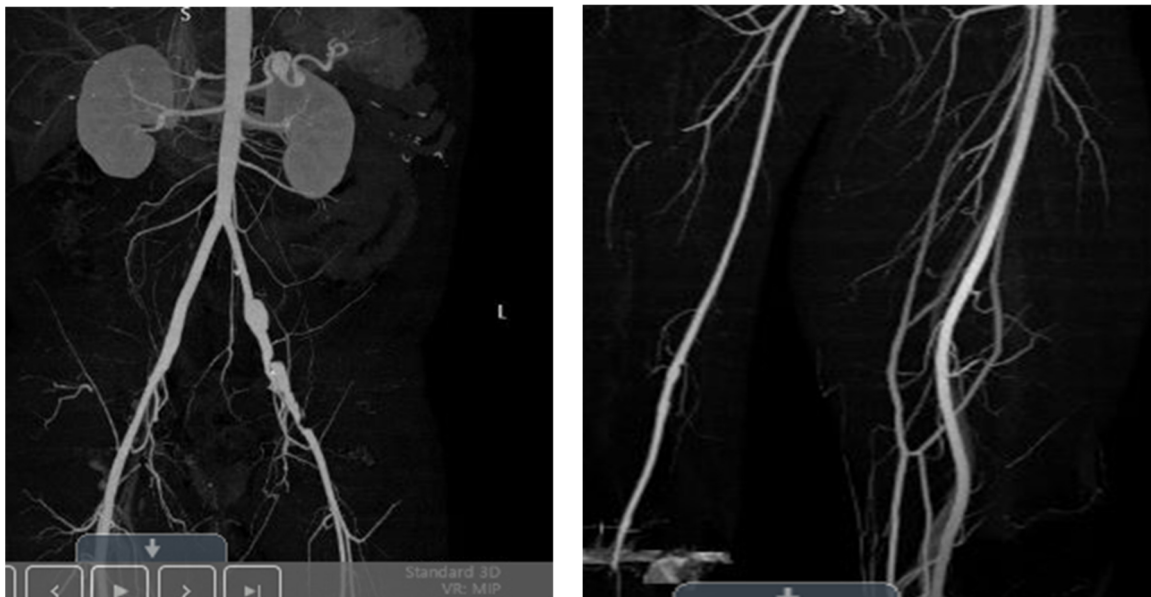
Images from CT angiogram abdomen and pelvis with B/L runoff, showing multiple arterial aneurysms and thrombotic occlusion. Active arterial extravasation from the L. posterior tibial artery just distal to its origin from the tibioperoneal trunk w/surrounding facial and subcutaneous edema. May reflect a ruptured aneurysm, given patient’s history. Splenic artery and left common iliac artery aneurysms. Diffuse dilatation of the left external iliac artery 10 mm in diameter with an intimal dissection flap.
